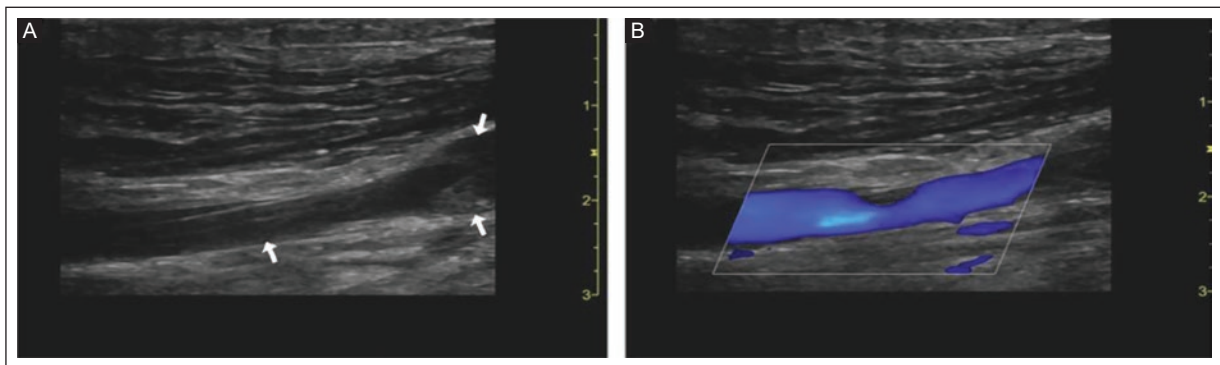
Grayscale (left) and color Doppler US (right) of a 49-year-old male patient with COVID-19. There is acute deep PICC-ASVT of the right upper extremity veins. A: several small thrombi are visible on the walls of the right axillary vein (white arrows). B: the vein is still permeable, and blood flow is normal. COVID-19: coronavirus disease 2019; PICC-ASVT: peripherally inserted central catheter-associated symptomatic venous thrombosis; US: ultrasound.
